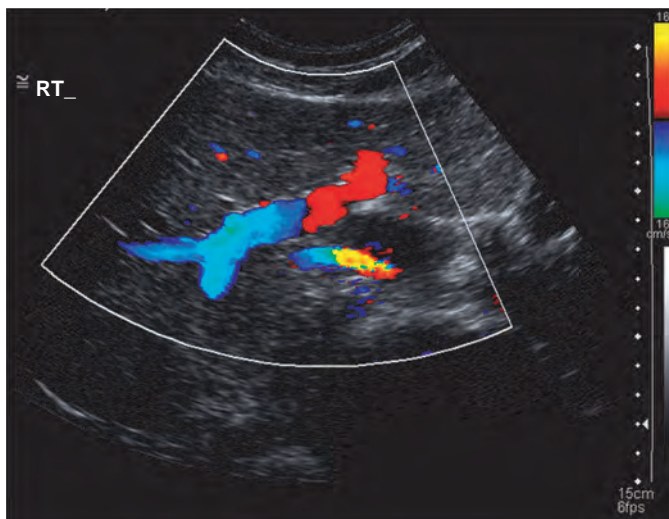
Color Doppler ultrasound scan showing normal flow in the left and right branches of the portal vein. Red represents flow toward the transducer, and blue, flow away from the transducer.
